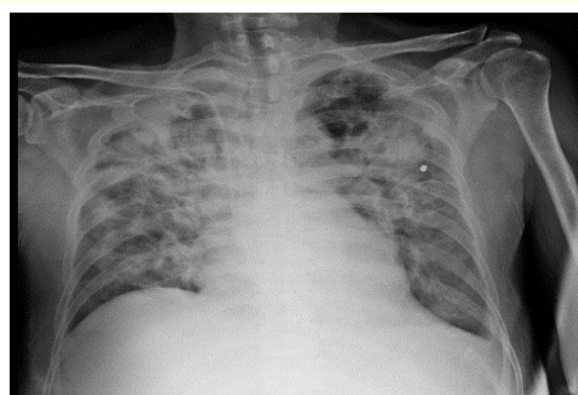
Chest X-ray on the 5th postoperative day.
